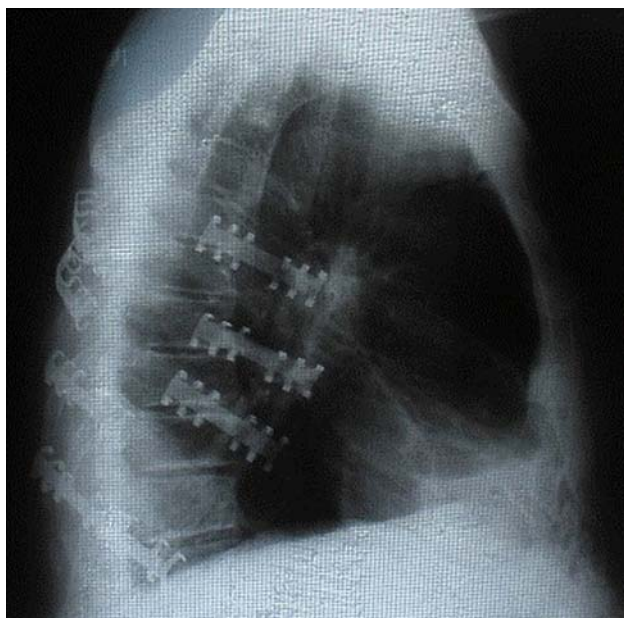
Lateral chest radiograph of multiple rib fractures repaired with Judet struts
